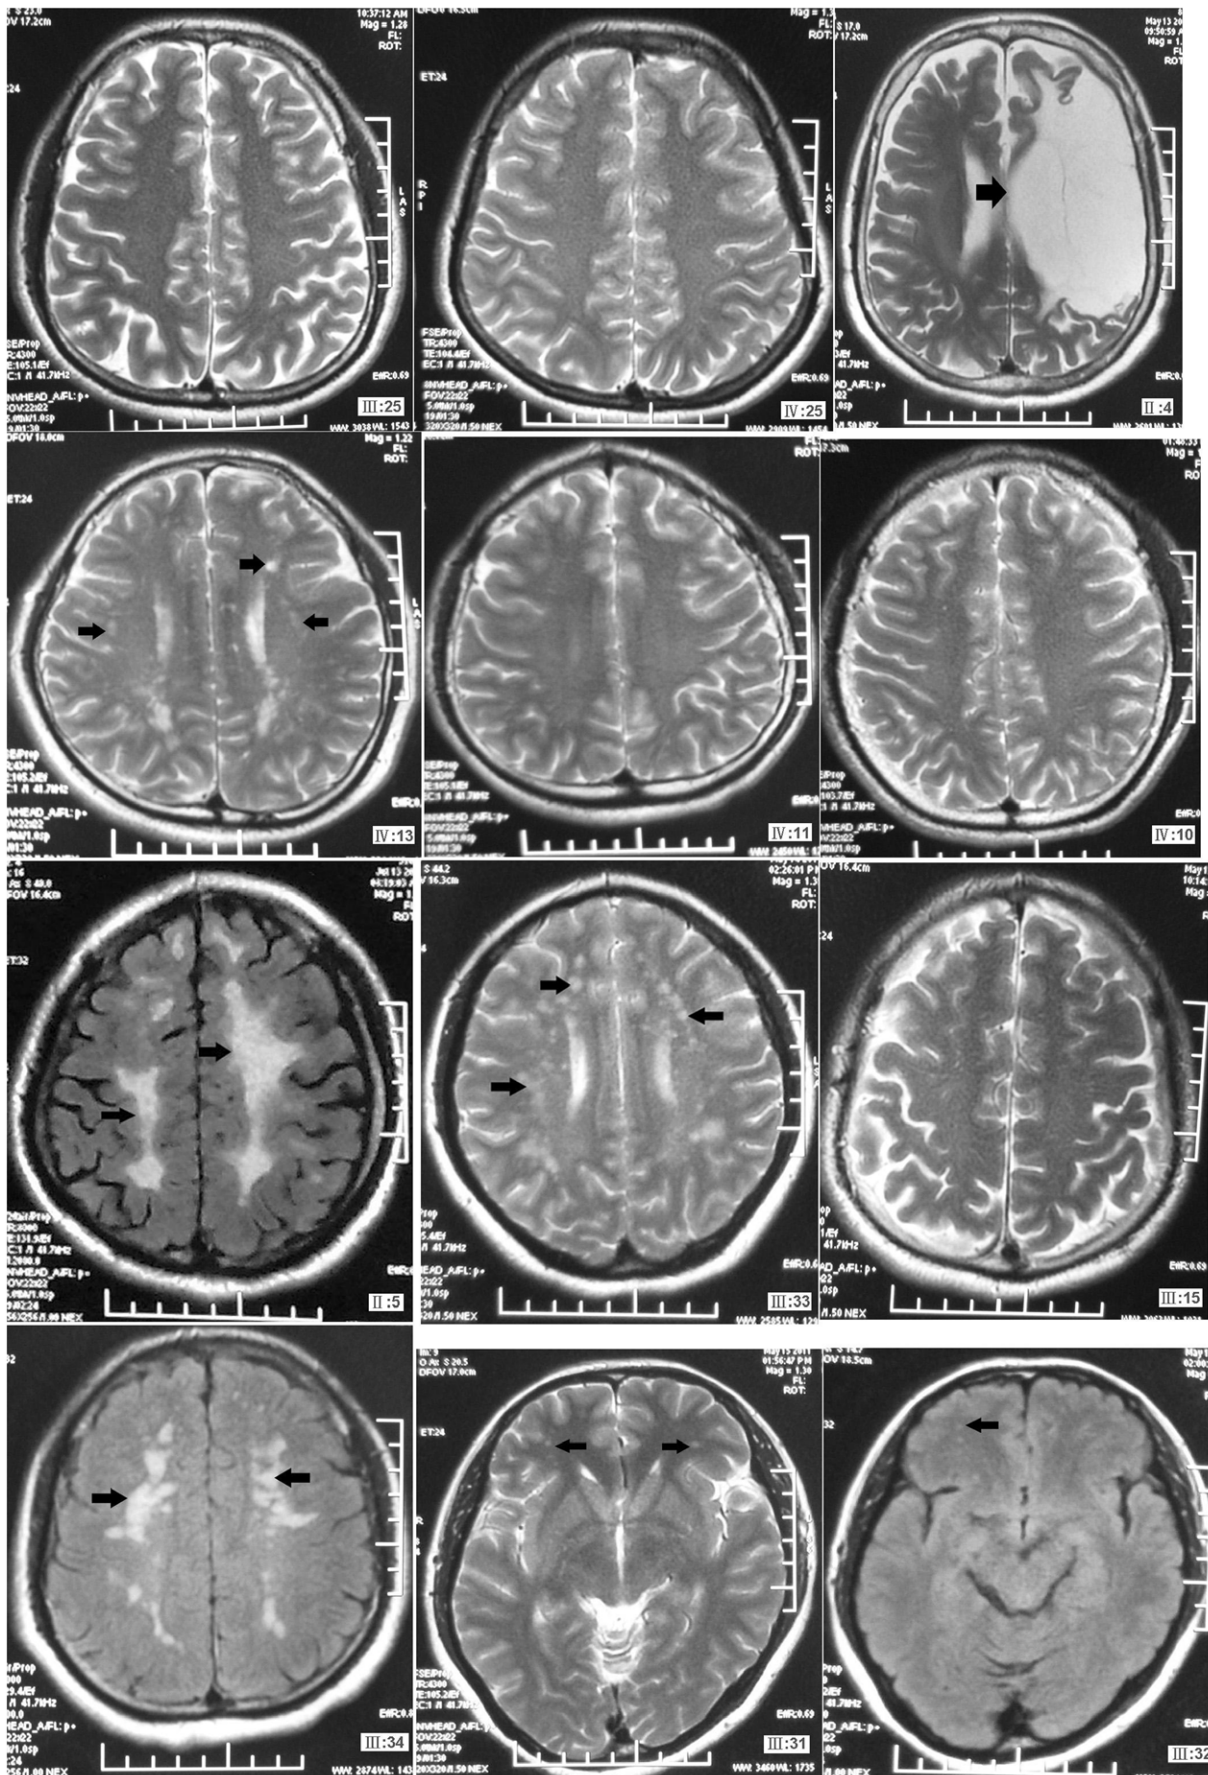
Cerebral MRI examination in the CADASIL family members. II:5, the proband, was a 60-year-old male affected family member. III:31, III:32, III:33 and III:34 were the children of the proband (II:5). II:5 and III:32 showed evident clinical features, but III:31, III:33 and III:34 did not show any clinical feature, although they were all mutation carriers (see the long T1 and T2 signals). III:25, III:15, IV:25, IV:10 and IV:11 were healthy core family members. III:4 is a patient with 1 massive cerebral infarction, who did not have the R133C mutation.
